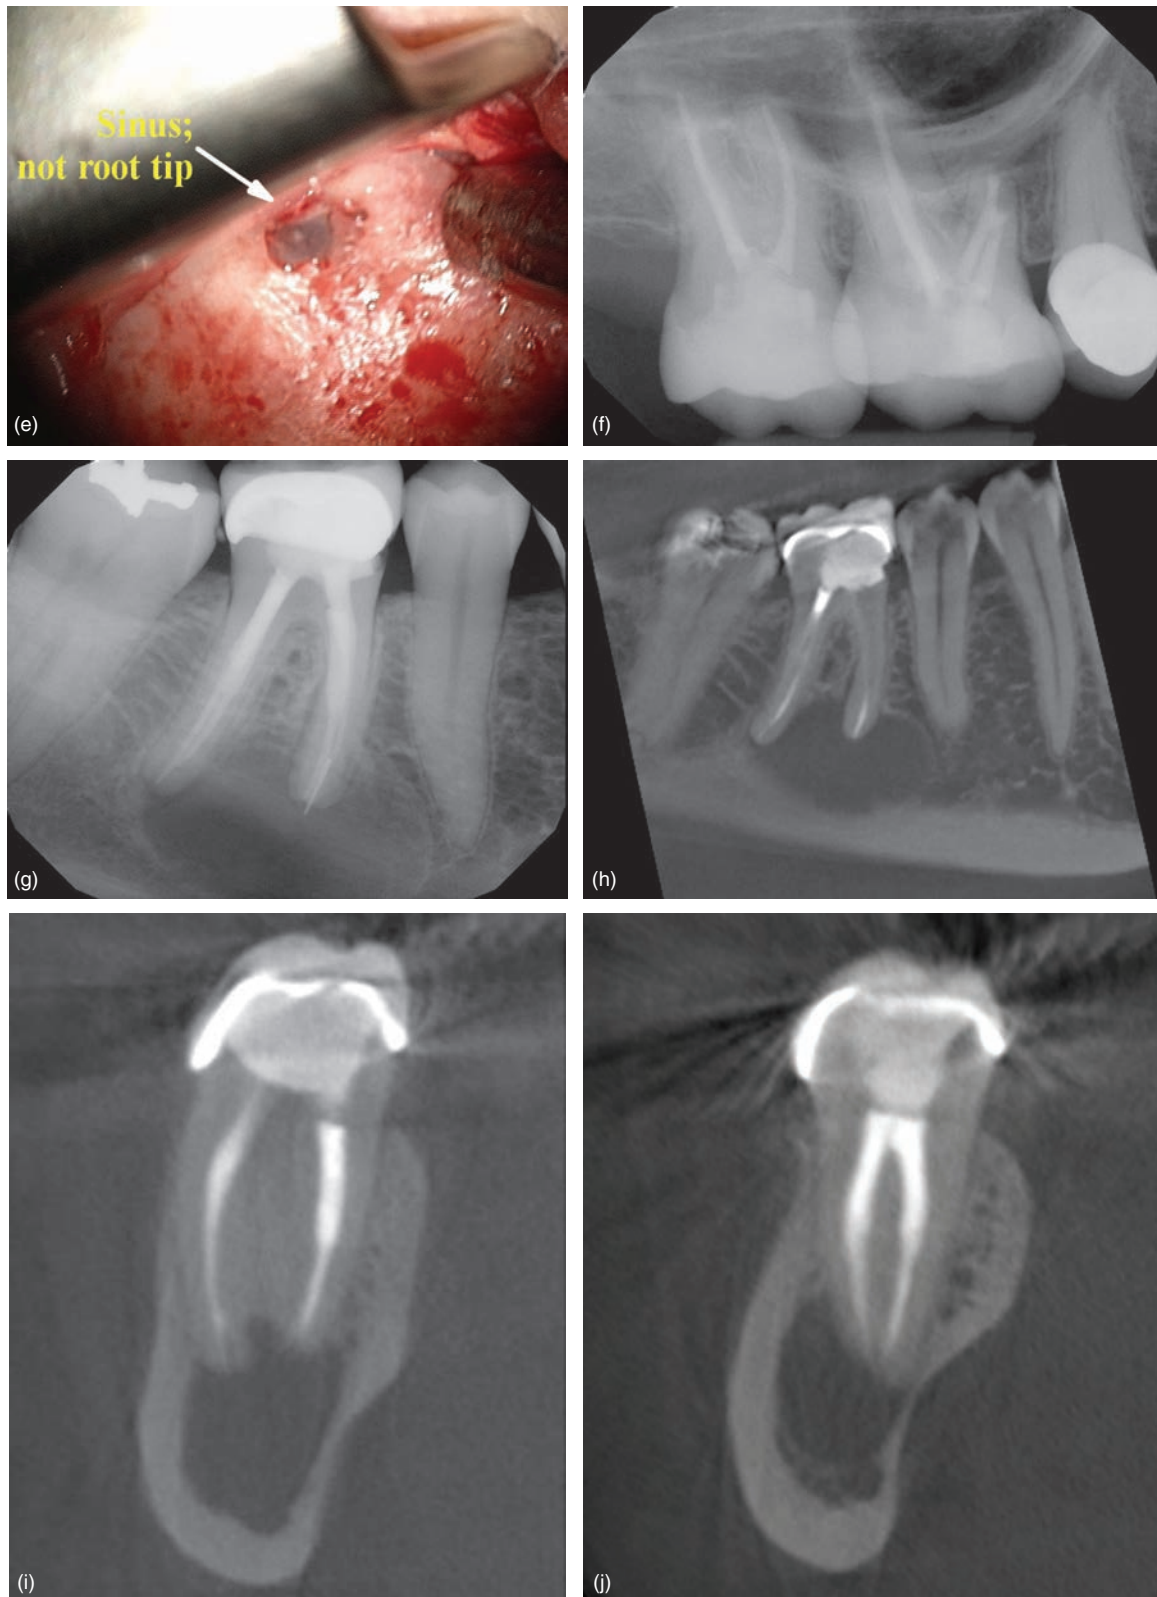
(Continued) (e) Due to patient's persistent symptoms, surgical retreatment was planned. Intraoral picture showing exposed sinus from a previous sinus surgical site. (f) Postoperative radiograph showing resected MB root and root end fillings. (g) Periapical radiograph showing mandibular molar with a separated instrument and large radiolucent area. Due to the location of the separated instrument and the size of lesion, a surgical approach was opted for. (h) Sagittal view showing a large low-density area including the mandibular nerve. (i) Coronal view showing the extent of lesion around the mesial root. (j) Coronal view showing the extent of lesion around the distal root.
